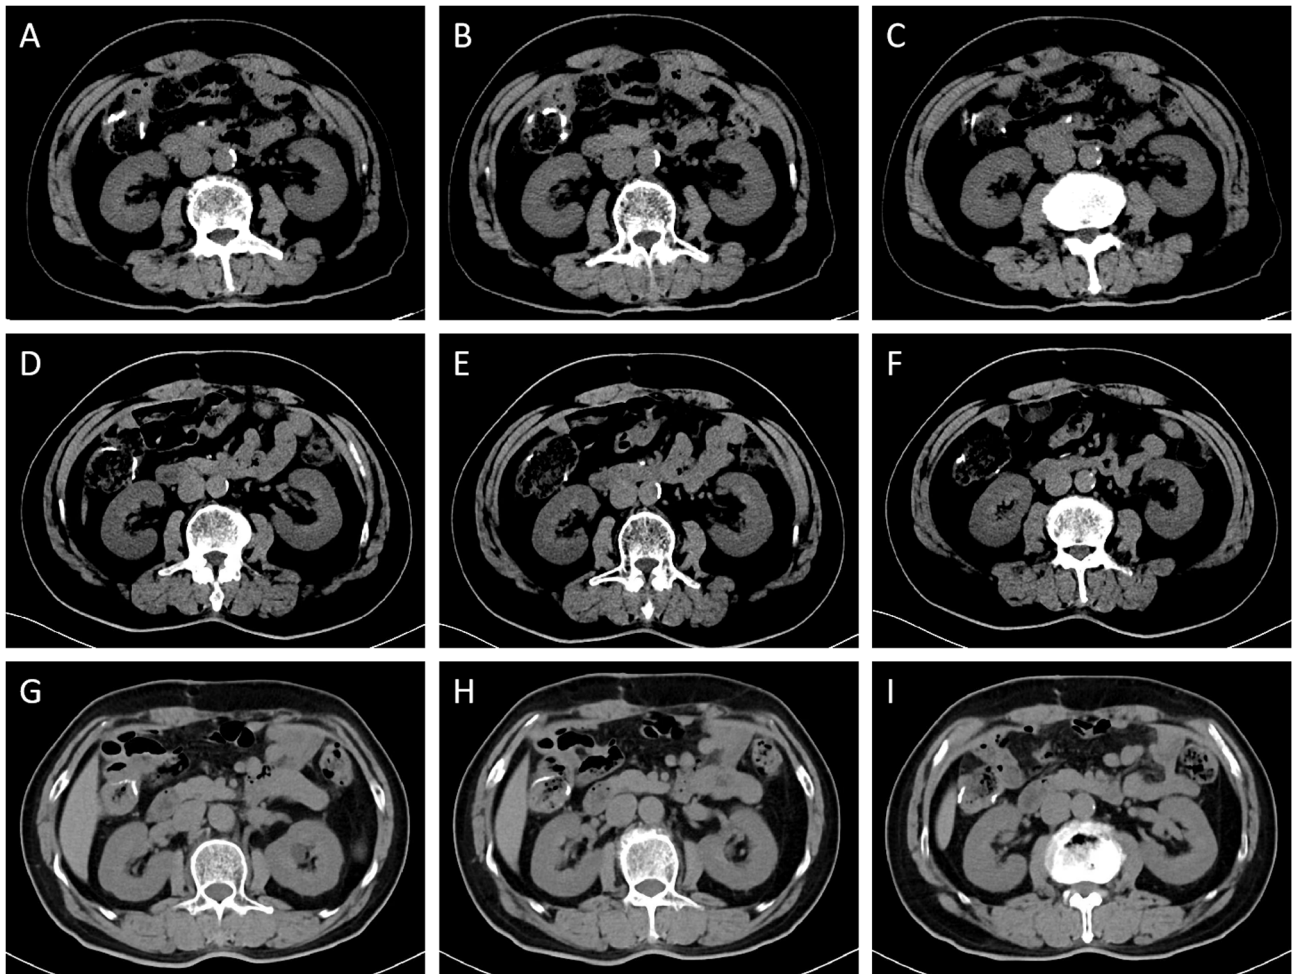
CT examination results of the 3 patients within 1 year of the operation did not reveal any imaging signs of disease progression or recurrence. The highlighted linear shadows in the images represent the nails of the intestinal stapler. Continuous CT images show the conditions around the intestinal anastomosis. (A-C) The CT examination performed in August 2023. (D-F) The CT examination performed in February 2024. (G-I) The CT examination performed in June 2024.
